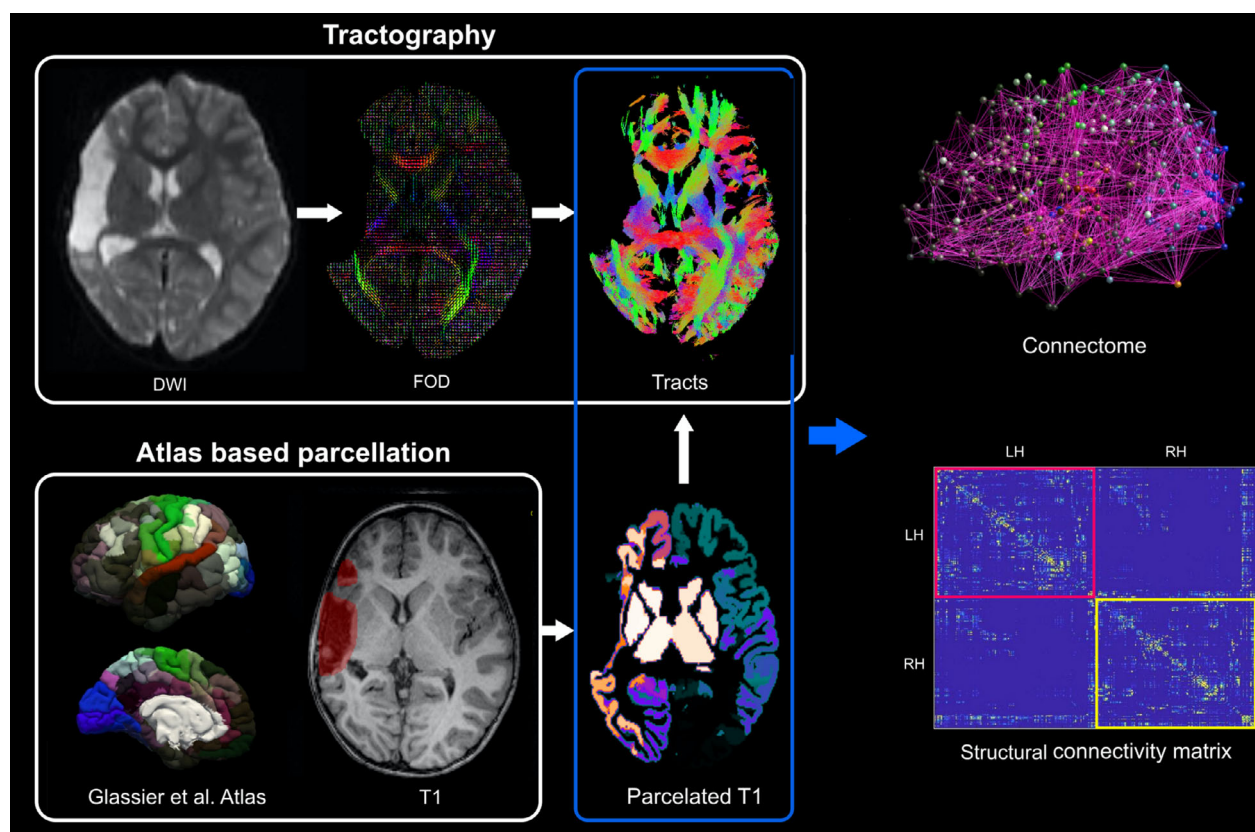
Overview of the methodology. The creation of the structural connectivity matrix consists of different steps. These steps include the processing of T1-weighted images (second row) with FreeSurfer and FSL as well as diffusion-weighted images with MRtrix3 (first row). The obtained connectivity matrix consists of 379×379 connections weights.
